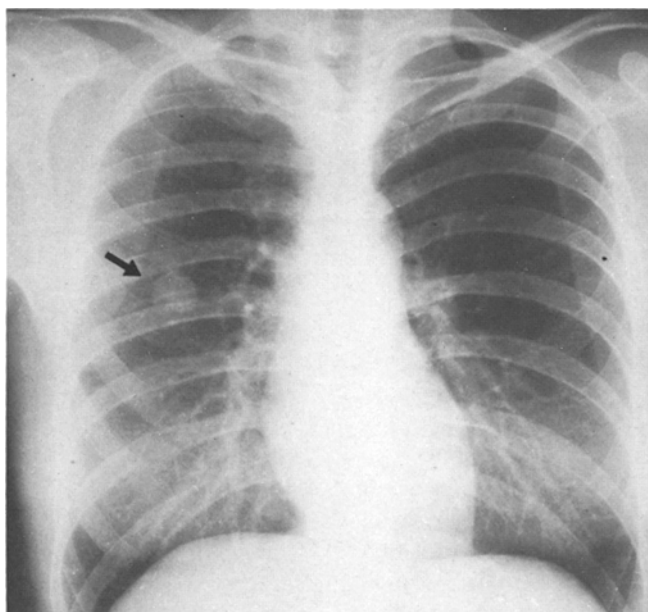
Radiographic appearance of a sclerosing angioma (arrow) of the lung
